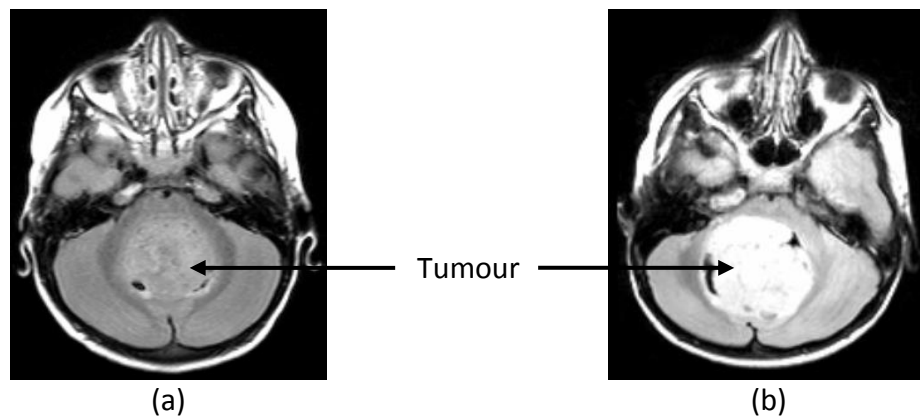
Comparison of two FLAIR images of medulloblastoma cases which have different signal intensity level compared to normal tissues. (a) The tumour is isointense to normal tissues (case MB719). (b) The tumour is hyperintense to normal tissues (case MB532).
